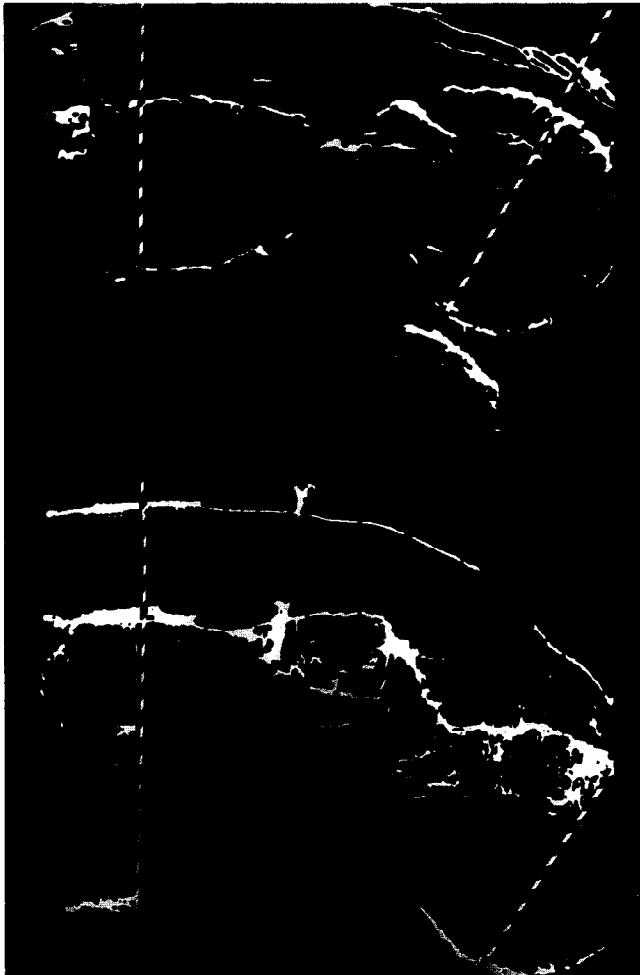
Ultrasound pictures from the early 1970s where two fetuses at 38/39 weeks' gestation are compared. The upper one is dystrophic (small for gestational age), the lower one macrosomic due to maternal diabetes
